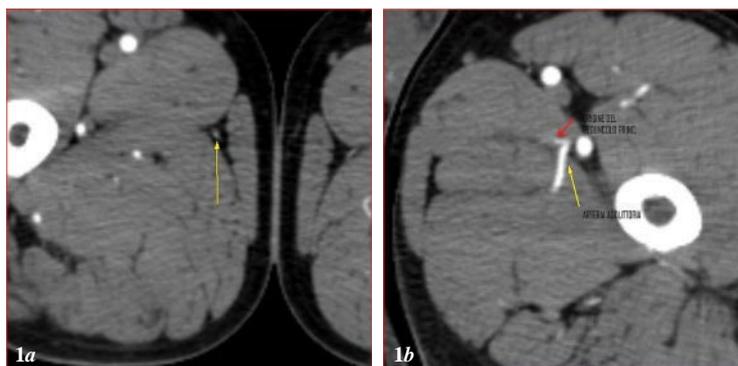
a) Transverse image of CT angiography at the level of the point of entry of the main pedicle into the gracilis muscle (yellow arrow). b) Transverse image of CT angiography showing the origin of the dominant pedicle for gracilis muscle from the artery for the adductors.
